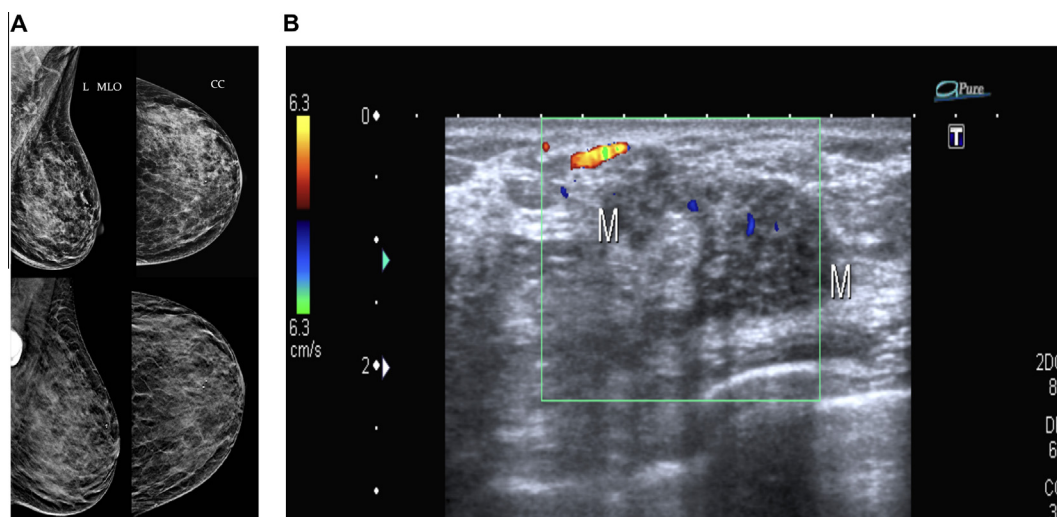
Patient is 58 years old with history of right breast cancer post mastectomy. One year post therapy follow-up revealed contralateral ductal carcinoma in situ (DCIS) solid and cribriform patterns with stromal microinvasion. (A) Left-sided FFDM and tomosynthesis MLO and CC views show unremarkable findings. (B) Color Doppler US shows ill-defined area of abnormal hypoechoic texture. Note small feeding vessel targeting the lesion. According to the mammography the breast is BI-RADS 1 yet US displays BI-RADS 4a which is the nearer category to the pathology results.
